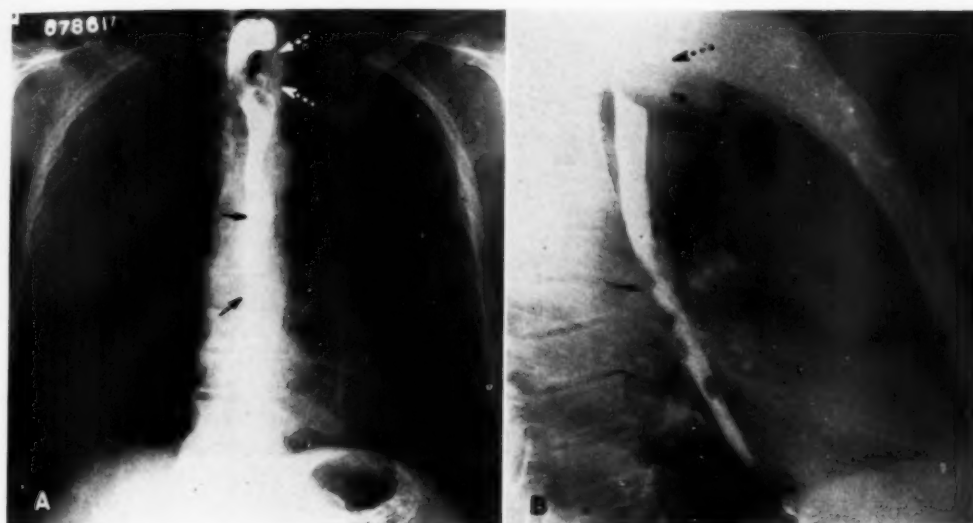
Left paratracheal lymph nodes. A 66-year-old white male had experienced progressive dysphagia and hoarseness for five weeks prior to admission. A barium swallow disclosed the presence of an ulcerating, constricting tumor, which extended downward from the level of the tracheal bifurcation for a distance of 6 cm. This is seen on the postero-anterior grid (A) and lateral (B) roentgenograms (solid arrows). A soft-tissue tumor in the left paratracheal area was also observed. It compresses and indents the left side of the trachea as well as the left side of the esophagus. This is believed to represent enlargement of the left paratracheal lymph nodes (dotted arrows). Because of this evidence of lymphatic spread, as well as of left vocal cord paralysis, the patient was not explored.
